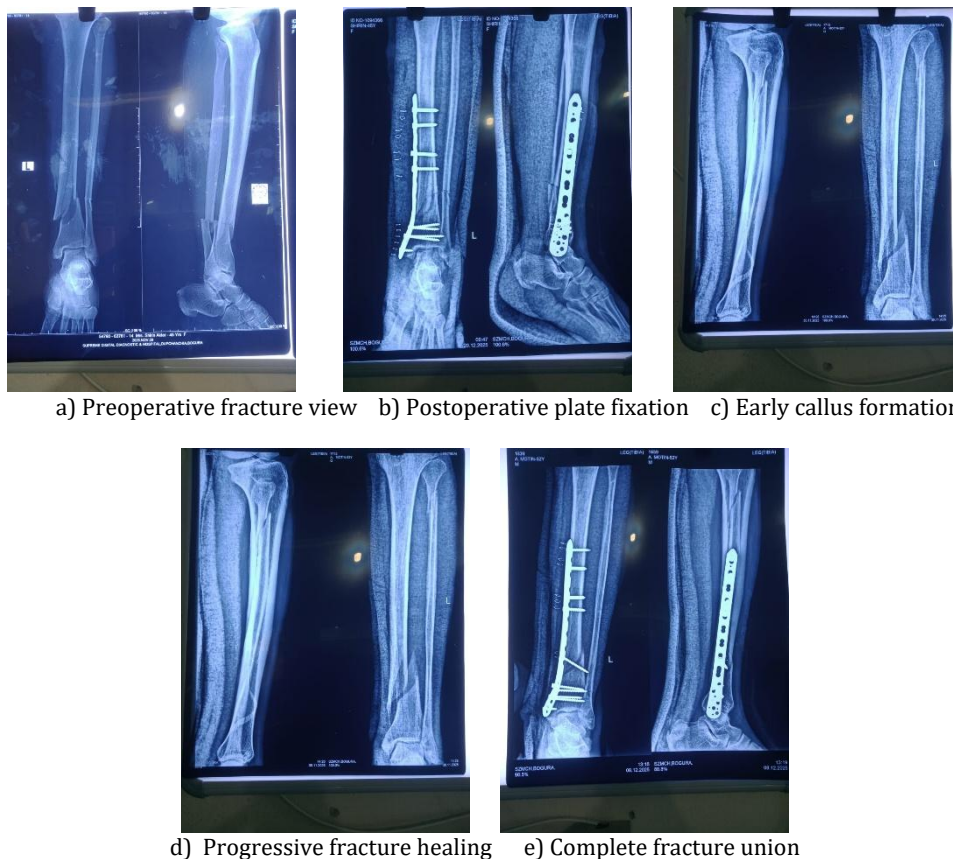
Radiographic evaluation of distal tibial fracture before and after surgical management showing plating fixation and subsequent healing.
